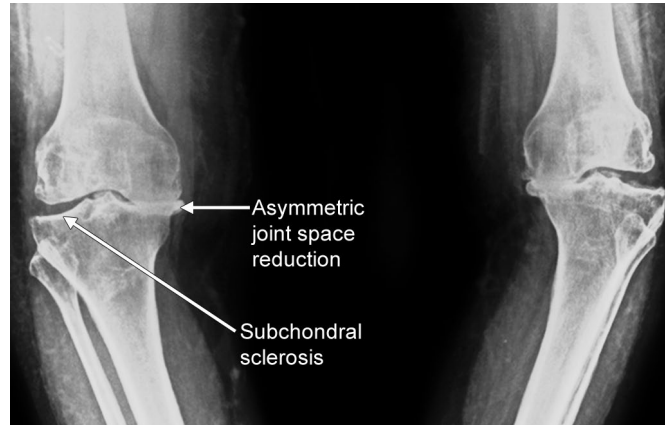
X-ray knee showing signs of osteoarthritis.
